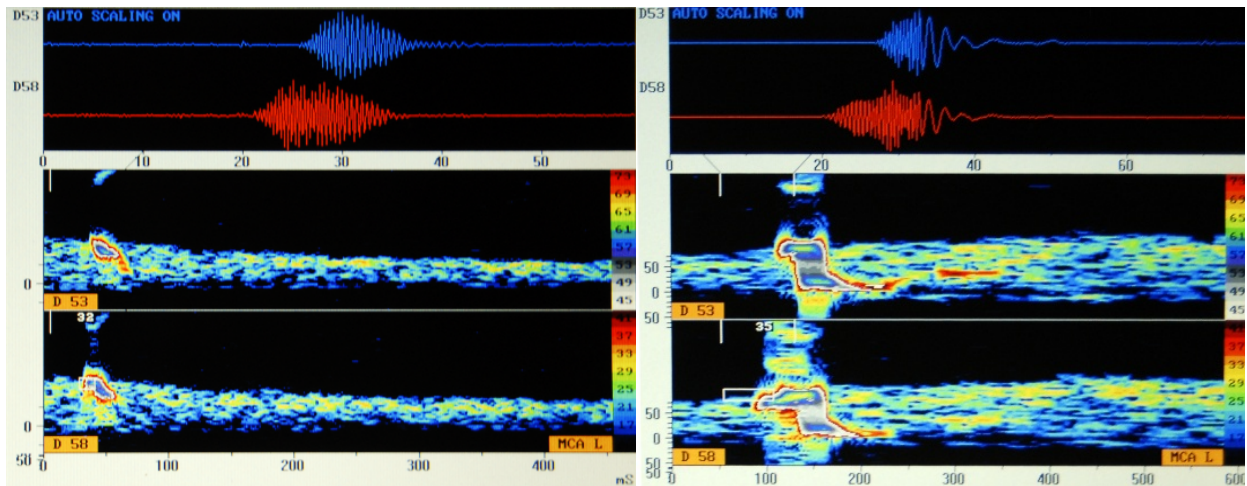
Left: An embolic signal was detected at a depth of 58mm with a relative intensity increase of 32dB. The software also detected the velocity of the embolic signal (73.7cm/s). The time lag in occurrence of the two signals is also visible on a pre-FFT signal at the bottom. There is a lag of 7ms between the peaks of the two signals. This difference indicates that the embolus has traveled 5.16mm from the first to second sample volume [6ms*737mm/1000ms=5.16mm]. The expected preset difference was 5mm. On the right: emboli showing higher ultrasound scattering and frequency shift counted as gaseous emboli in the study.
